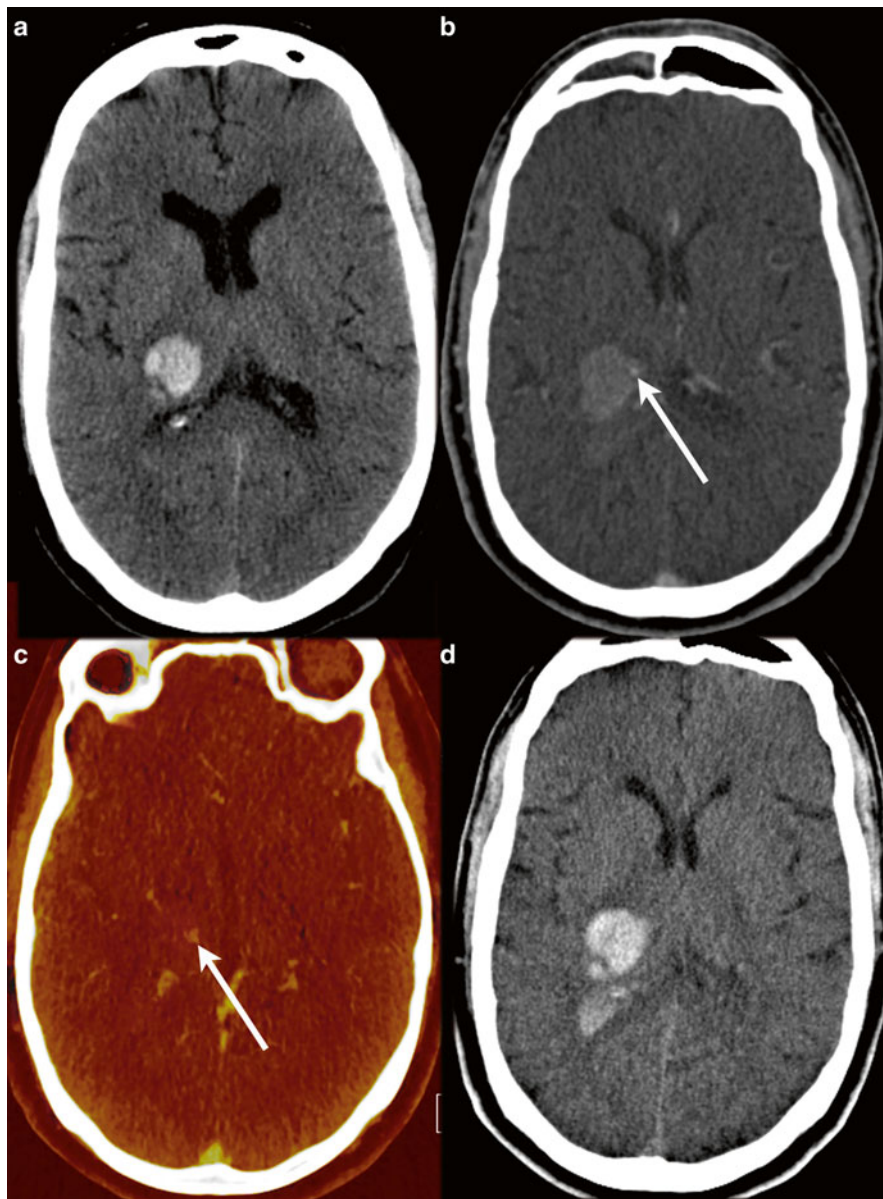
A 58 y/o male presented with left-sided hemiparesis and headache. NECT shows hemorrhage in the right thalamic region (a). Due to progression of symptoms CT with DE-CTA was repeated within 2 h. NECT demonstrates progression of the hemorrhage (d), extending into the lateral ventricle. A contrast spot is seen at the source images of the CTA at the level of the hemorrhage, consistent with the spot sign (b). This is even better depicted on the fused image, post-processed from the DE-CTA, where iodine is highlighted in yellow (c)
